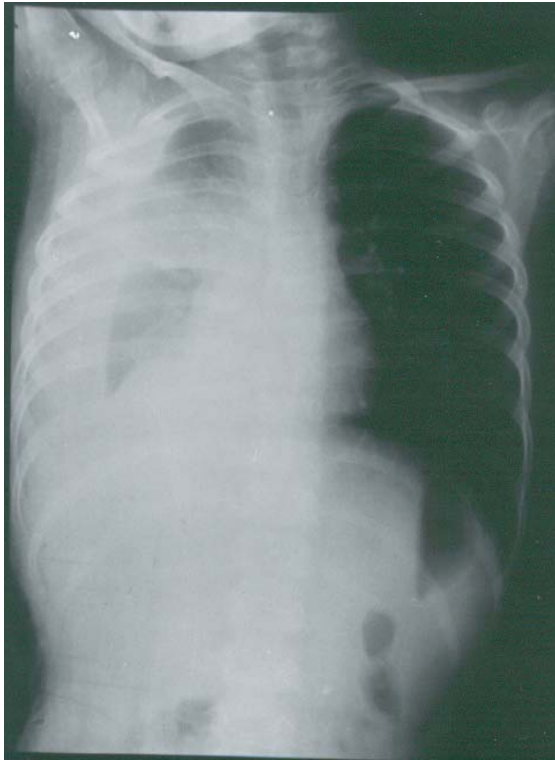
Chest radiograph at admission.
